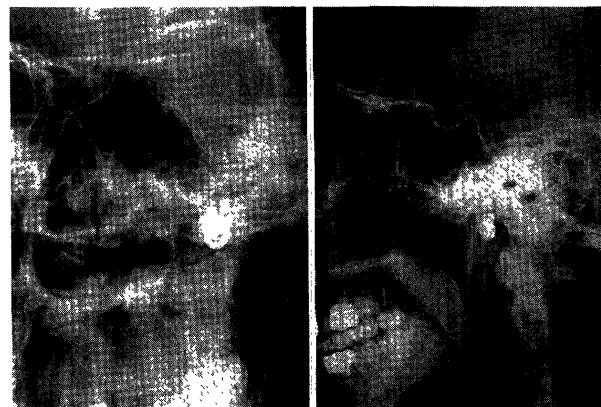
Plain x-ray films (*left*: anteroposterior view, *right*: lateral view) showing two mechanically detachable coils deposited within the aneurysm. Total length of the coils is 40 cm.
